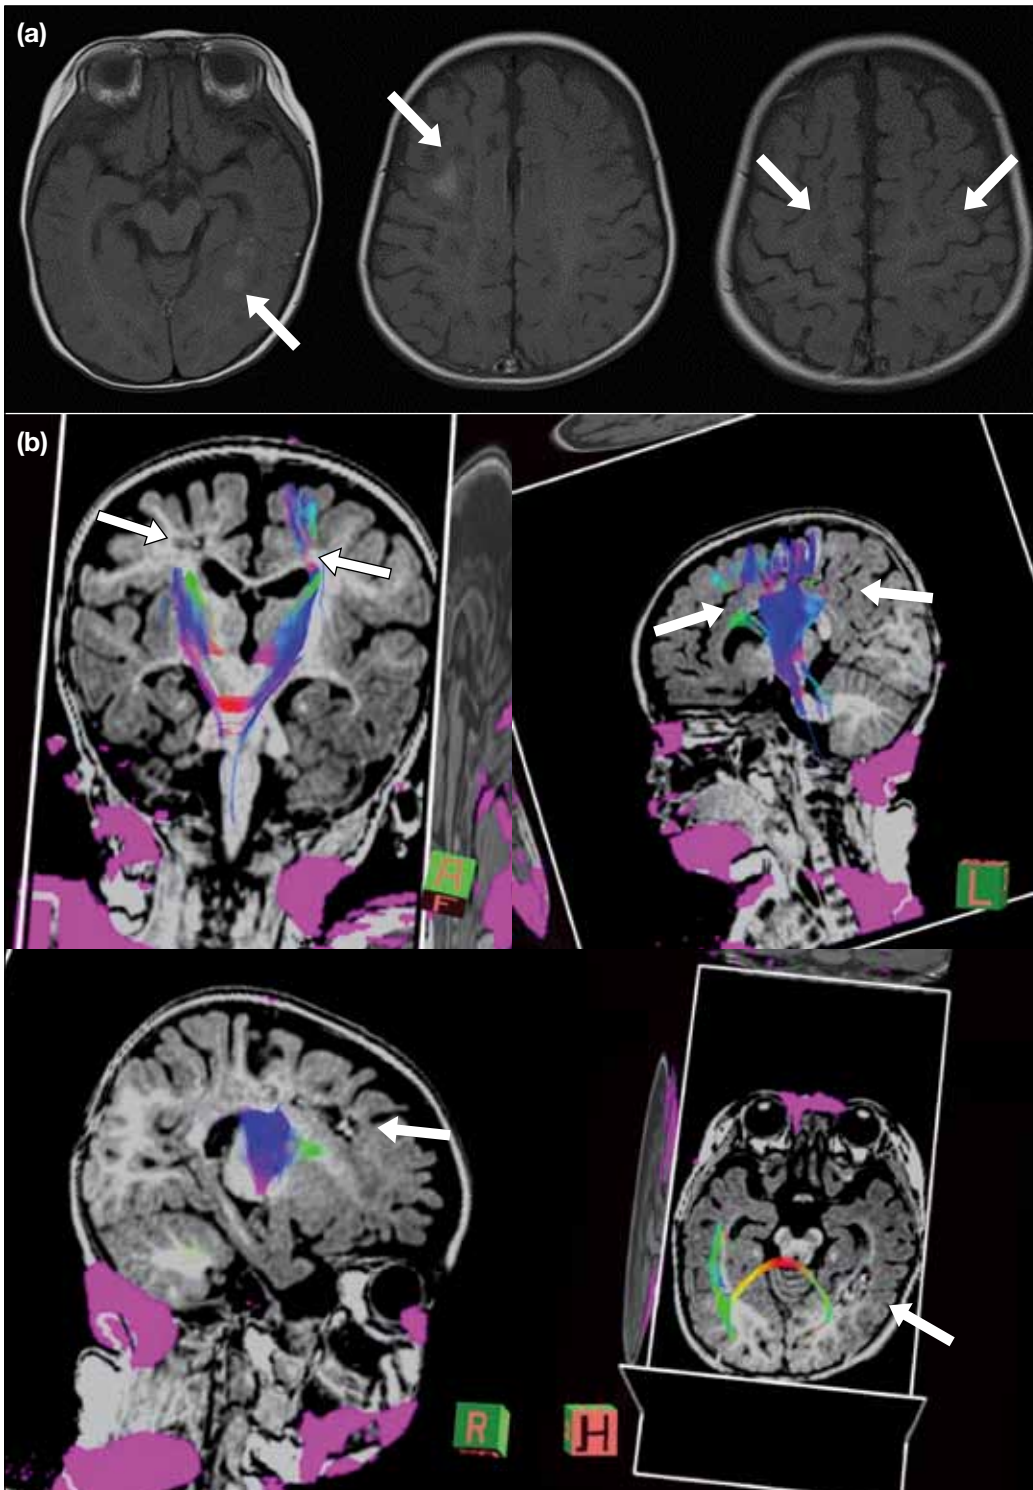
(a) T1-weighted images of a patient with suspected incontinentia pigmenti showing haemorrhagic necrosis (arrows). (b) Fibre-tractography showing involvement of bilateral corticospinal tracts and left inferior longitudinal fasciculus which is composed partly from the optic radiation (arrows).
